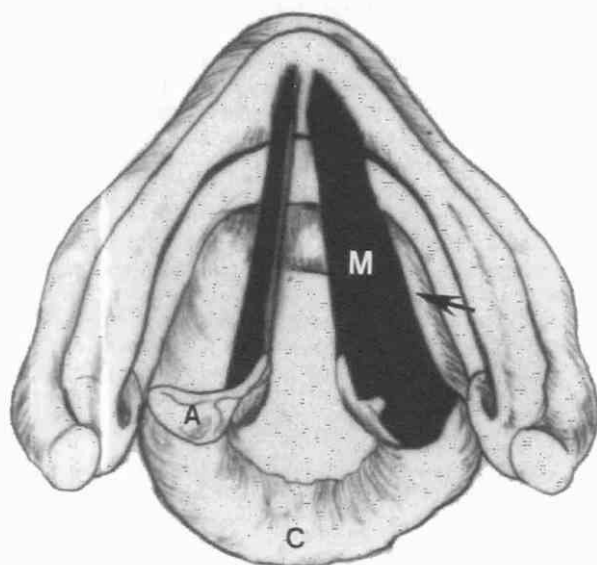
View from above, looking down at the skeletonized larynx. The thyroarytenoid muscle (M) is seen stretching from the arytenoid to the thyroid cartilage. Arrow indicates the point where paraglottic spread of tumor is expected to intersect the lateral cord. The opposite side shows the vocal ligament stretching from the vocal process of arytenoid to the thyroid cartilage. A, arytenoid; C, cricoid. (From Curtin HD: MR and CT of the larynx. In Thrall JH [ed]: *Current Practice of Radiology*, 3rd ed. St. Louis, Mosby-Year Book, 1994.)
